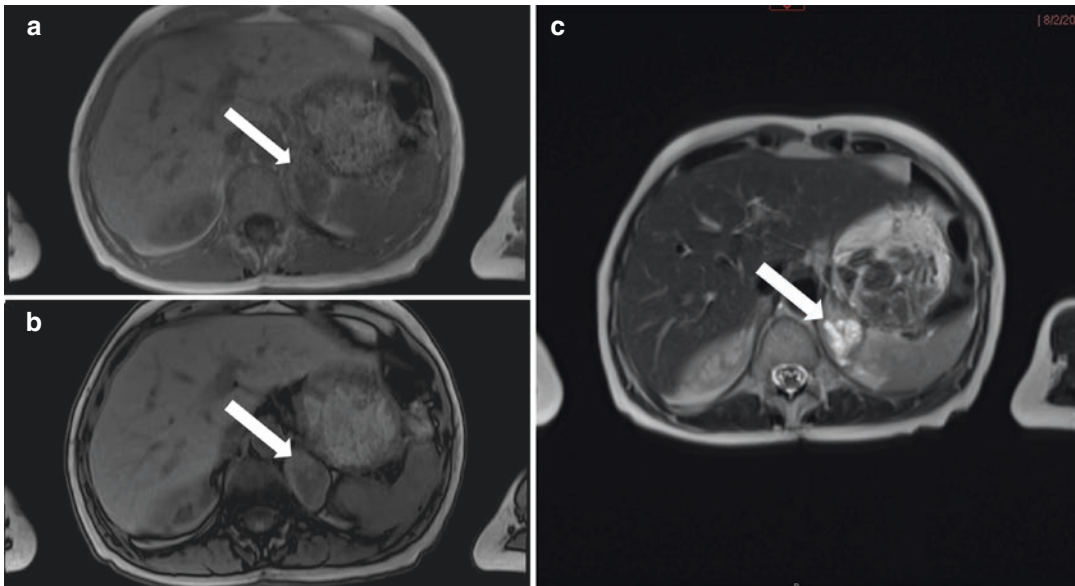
MRI images of a pheochromocytoma (white arrows). Key: (a) T1 weighted MRI of the Abdomen In-phase with arrow pointing to pheochromocytoma at the left adrenal gland; (b) T1 weighted MRI of the Abdomen Out-phase with arrow pointing to pheochromocytoma at the left adrenal gland; (c) T2
